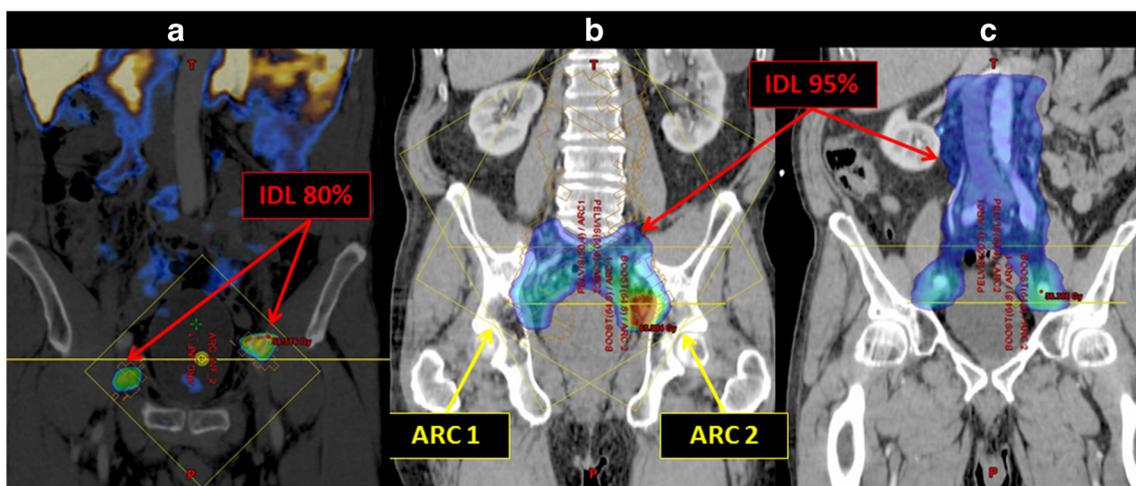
Techniques of salvage involved field nodal radiotherapy (s-IFRT) and salvage extended field nodal radiotherapy (s-EFRT) in an example patient with two FCH PET-positive pelvic LN. a s-IFRT with linear accelerator-based stereotactic body radiation therapy. Coronal superimposed FCH PET/CT image shows two FCH PET-positive pelvic LN: a left external iliac LN and another smaller right external
